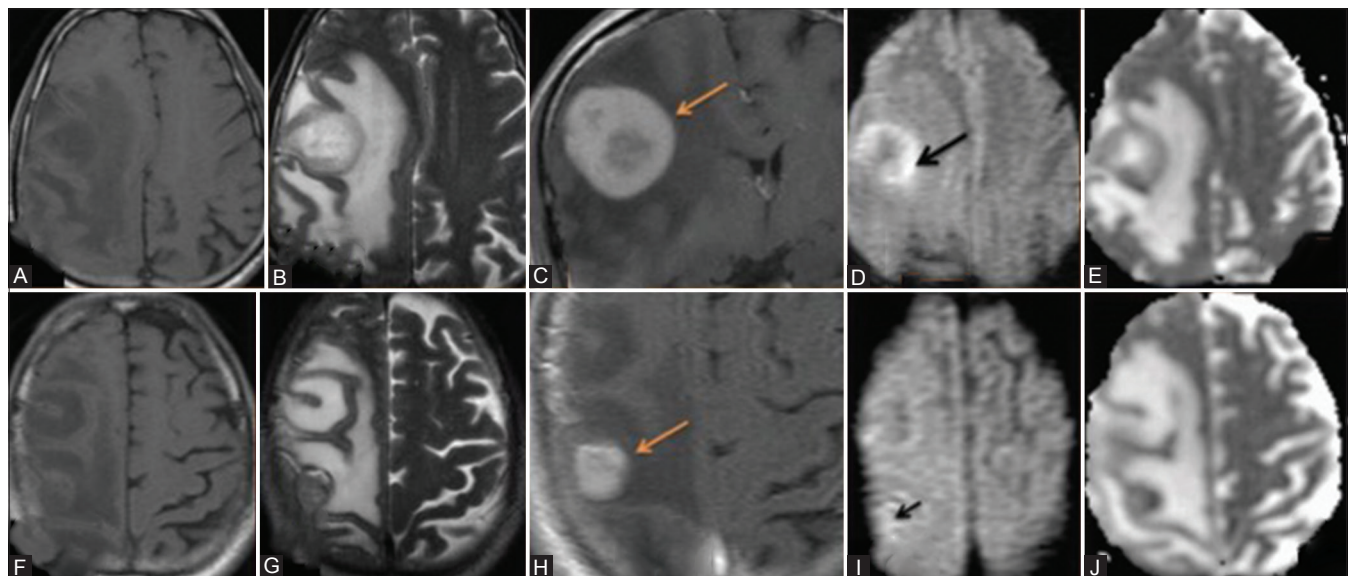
(A-J): History – A 52-year-old immunocompetent male patient presented with focal seizures for 1 month. MRI showed two well-defined homogeneously enhancing lesions (arrows) in right frontal lobe, in cortical-subcortical location, both isointense on T1 images (A and F). The larger lesion showed central hyperintensity on T2 W image (B) and the smaller lesion was hypointense on T2 W image (G). There was peripheral rim enhancement (C) with peripheral restricted diffusion noted in the larger lesion on diffusion and ADC images (D and E) suggestive of central non-enhancing necrosis. The smaller lesion showed homogenous enhancement (H), complete restriction on diffusion and apparent diffusion co-efficient [ADC] images (I and J)
